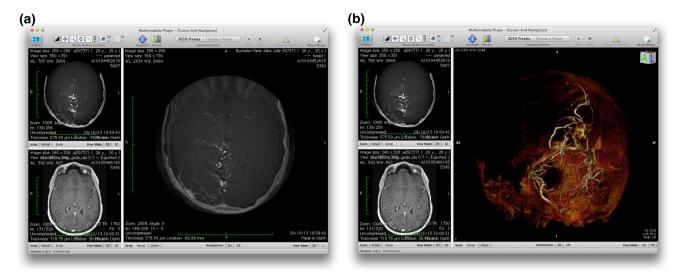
3D-3D registration and fusion patient case 1 (CTA + 3DRA) in 2D (a) and 3D (b) output mode
